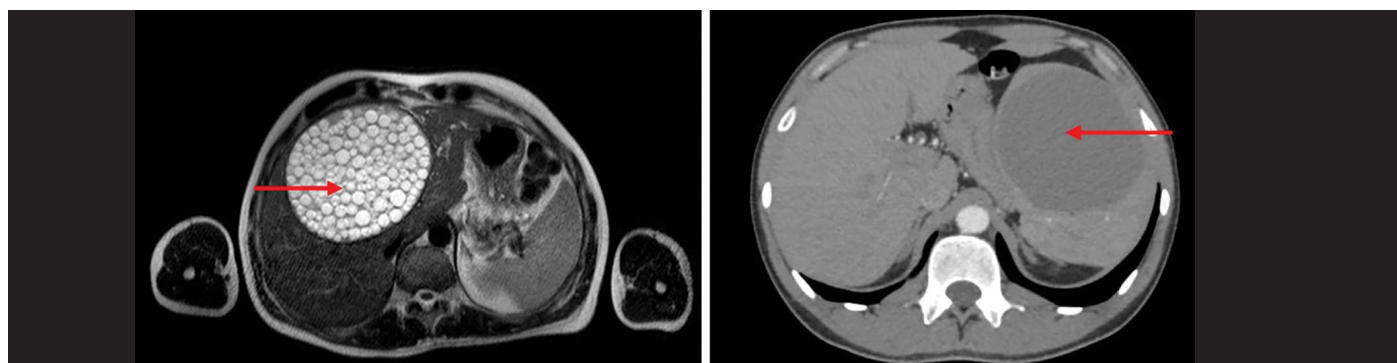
Cyst appearances on abdominal MRI and abdominal CT in 2 different patients with negative *Echinococcus* IHA
